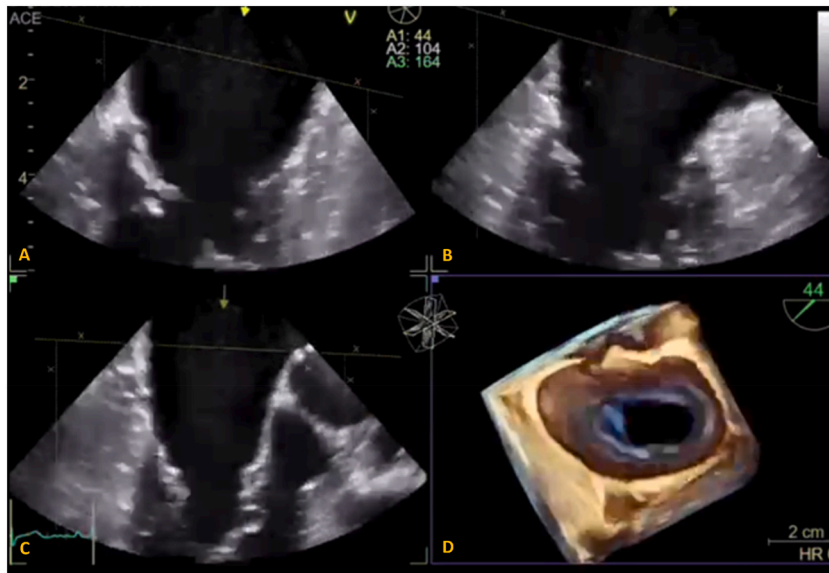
Multiple transesophageal ultrasound left atrium B-Mode (A,B,C) and 3D (D) views obtained at mid-esophageal level show a rare case of congenital absence of the LAA.
